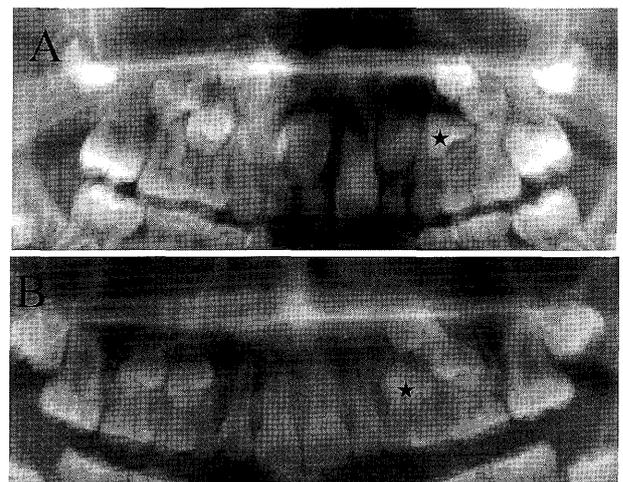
The initial orthopantomograms in Cases 9 and 10 of types C
